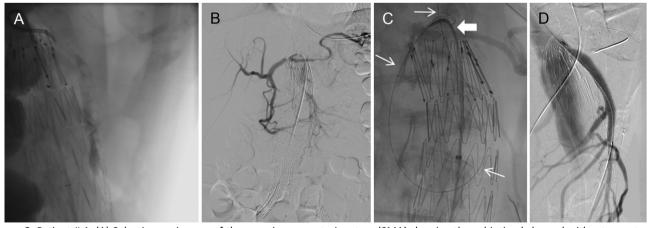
Patient # 1. (A) Selective angiogram of the superior mesenteric artery (SMA) showing the subintimal channel without re-entry in the true lumen distally. (B) Visualization of the celiac trunk (CT) with retrograde filling of the proximally occluded SMA. (C) Retrograde approach to the SMA through the pancreaticoduodenal arcade. The tip of a Headhunter Slip Cath catheter had been placed at the ostium of the previously stented CT (block arrow); a .014" guide wire (white arrows) was passed through the SMA and back into the aortic lumen by crossing the pancreaticoduodenal arcade in a retrograde fashion. A second Headhunter was then advanced over a parallel .018" wire (black arrow) distally to the occluded segment of the SMA. (D) Completion angiogram showing a fully expanded stent graft with no residual stenosis.
